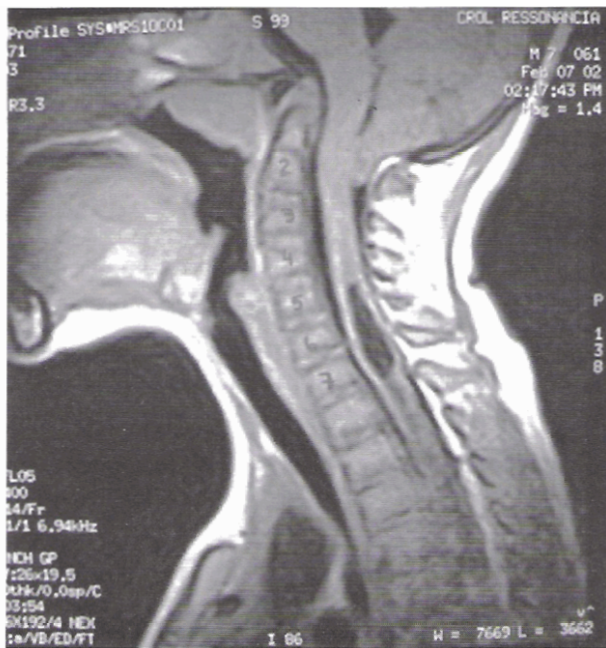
Magnetic resonance imaging showing basilar impression. Note the C2 odontoid process located above the Chamberlain line (a line traced between the posterior border of the hard palate and the posterior border of the foramen magnum).
